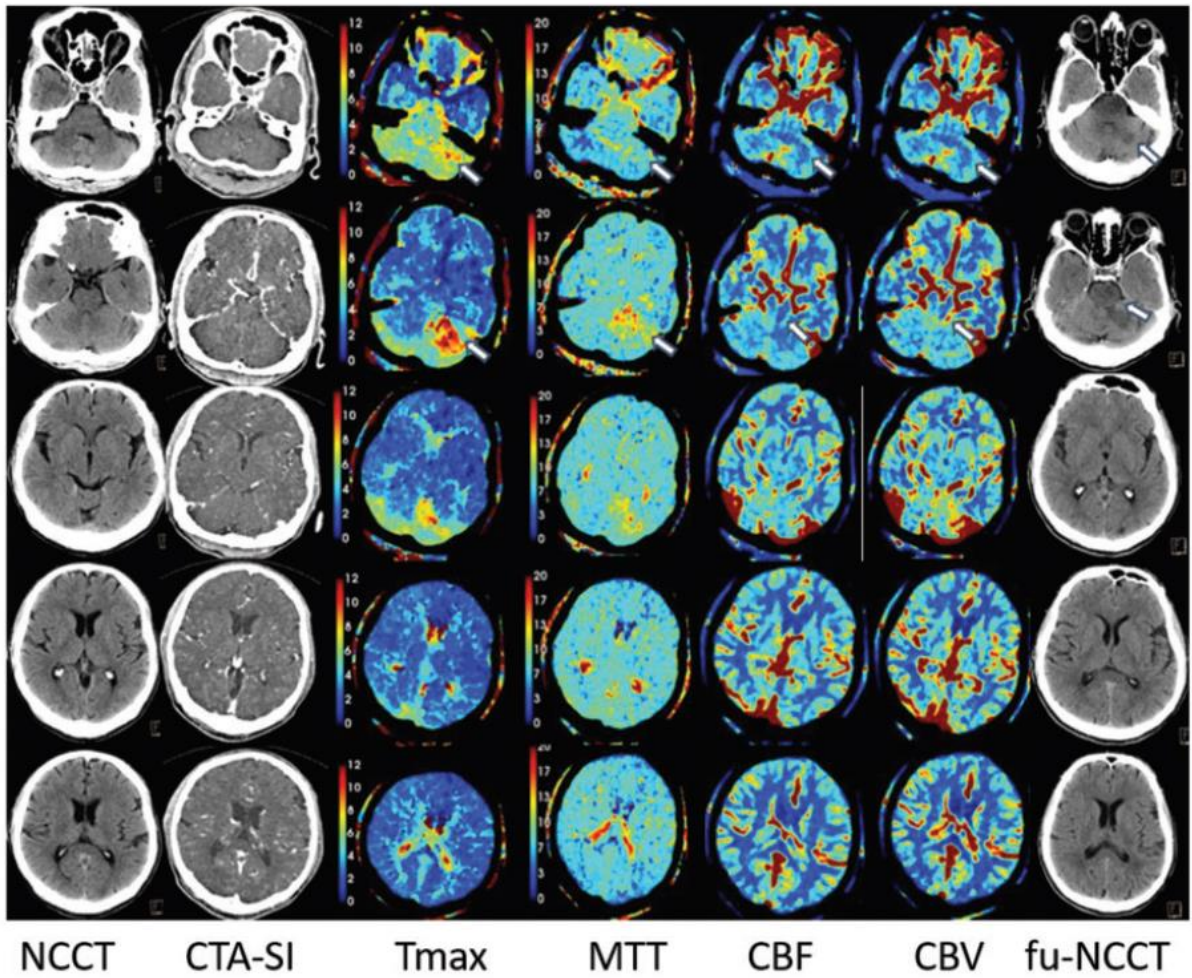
CBV pc-ASPECTS = 7 in patients with ischemic changes in the left cerebellum and brainstem on CTP maps. CBF: cerebral blood flow; CBV: cerebral blood volume; CTA-SI: CTangiography source images; fu-NCCT: follow-up NCCT; MTT: mean transit time; NCCT: non-contrast CT; Tmax: time to maximum of the deconvolved tissue-concentration curve.
